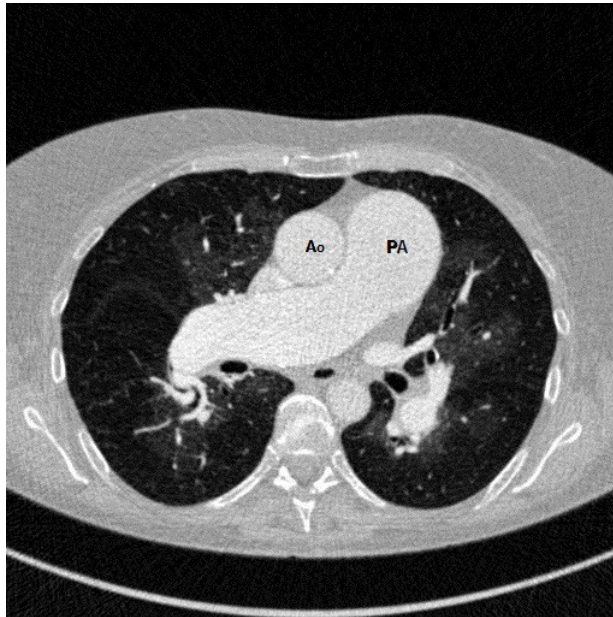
A representative CT scan of a patient from our PH pilot study showing the aorta (Ao) and the dilated main pulmonary artery (PA).
